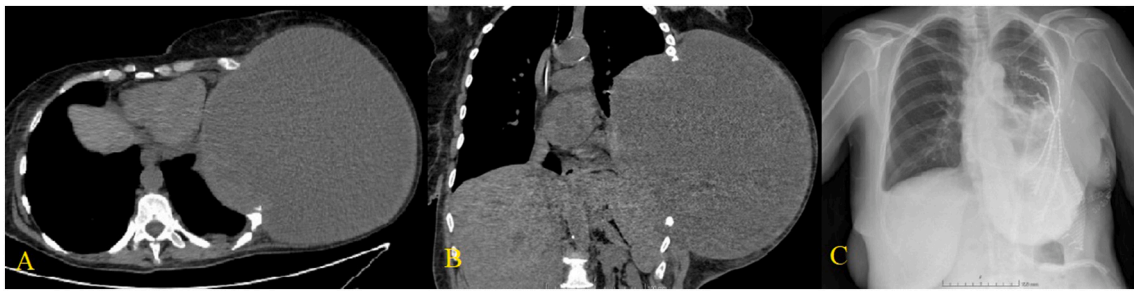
A: Updating CT scan before surgery axial plane. B: Updating CT scan sagittal plane of the lesion. C: Post-surgery chest x-ray.
